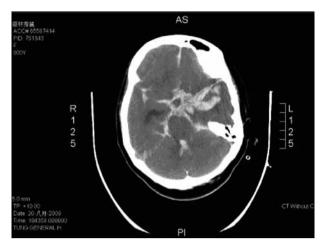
CT scan showed massive subarachnoid hemorrhage on left sylvian fissure.
